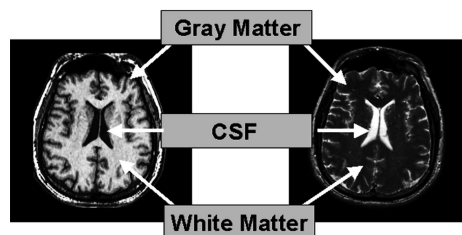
MR T1-weighted (left) and T2-weighted (right) axial views of the brain. In T1w images, gray matter is in gray, white matter in white, and CSF in black. In T2w images, the colors are inverted.
